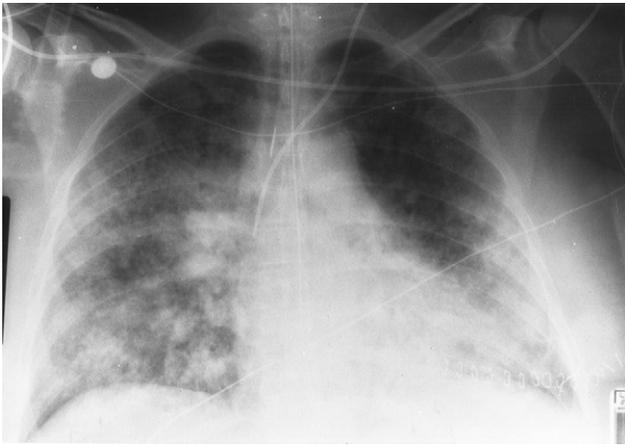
Candida* pneumonia in a leukemic with endotracheal tube, orogastric tube and central venous line. AP bedside chest radiograph shows generalized coalescing nodular airspace opacities. A recently performed open lung biopsy (skin staples overlie lower left chest) revealed *Candida albicans* pneumonia.
